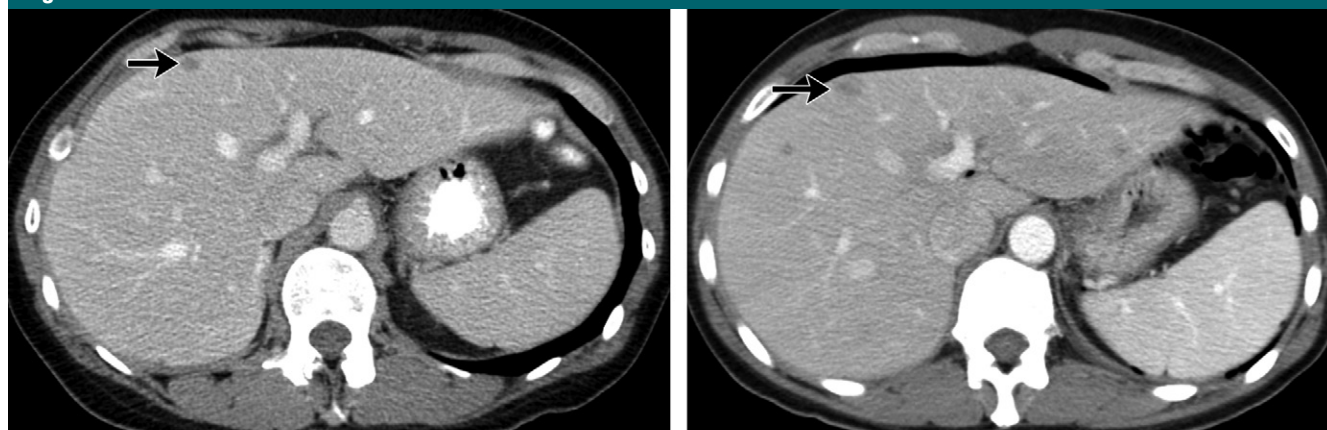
Severe acute pancreatitis of unknown origin in a 46-year-old woman. The patient was brought to the operating room to evaluate the pancreas and liver lesions. Intraoperative US (not shown) did not demonstrate a pancreatic lesion. Subsequent biopsy demonstrated poorly differentiated adenocarcinoma of unknown primary. Preoperative contrast-enhanced CT (not shown) demonstrated fullness of the pancreas. (a) Axial preoperative contrast-enhanced CT image shows multiple indeterminate hypoattenuating liver lesions, including an 8-mm segment IVb lesion (arrow). (b) Transverse intraoperative US image of segment IVb shows echogenic hepatic lesion consistent with hemangioma (arrow). Additional hepatic lesions showed similar appearance at intraoperative US. Therefore no biopsy was performed. (c) Axial contrast-enhanced multidetector CT image from follow-up examination performed 1 month later shows interval growth of the segment IVb lesion (arrow). New hypoattenuated lesions (not shown) had also developed.
